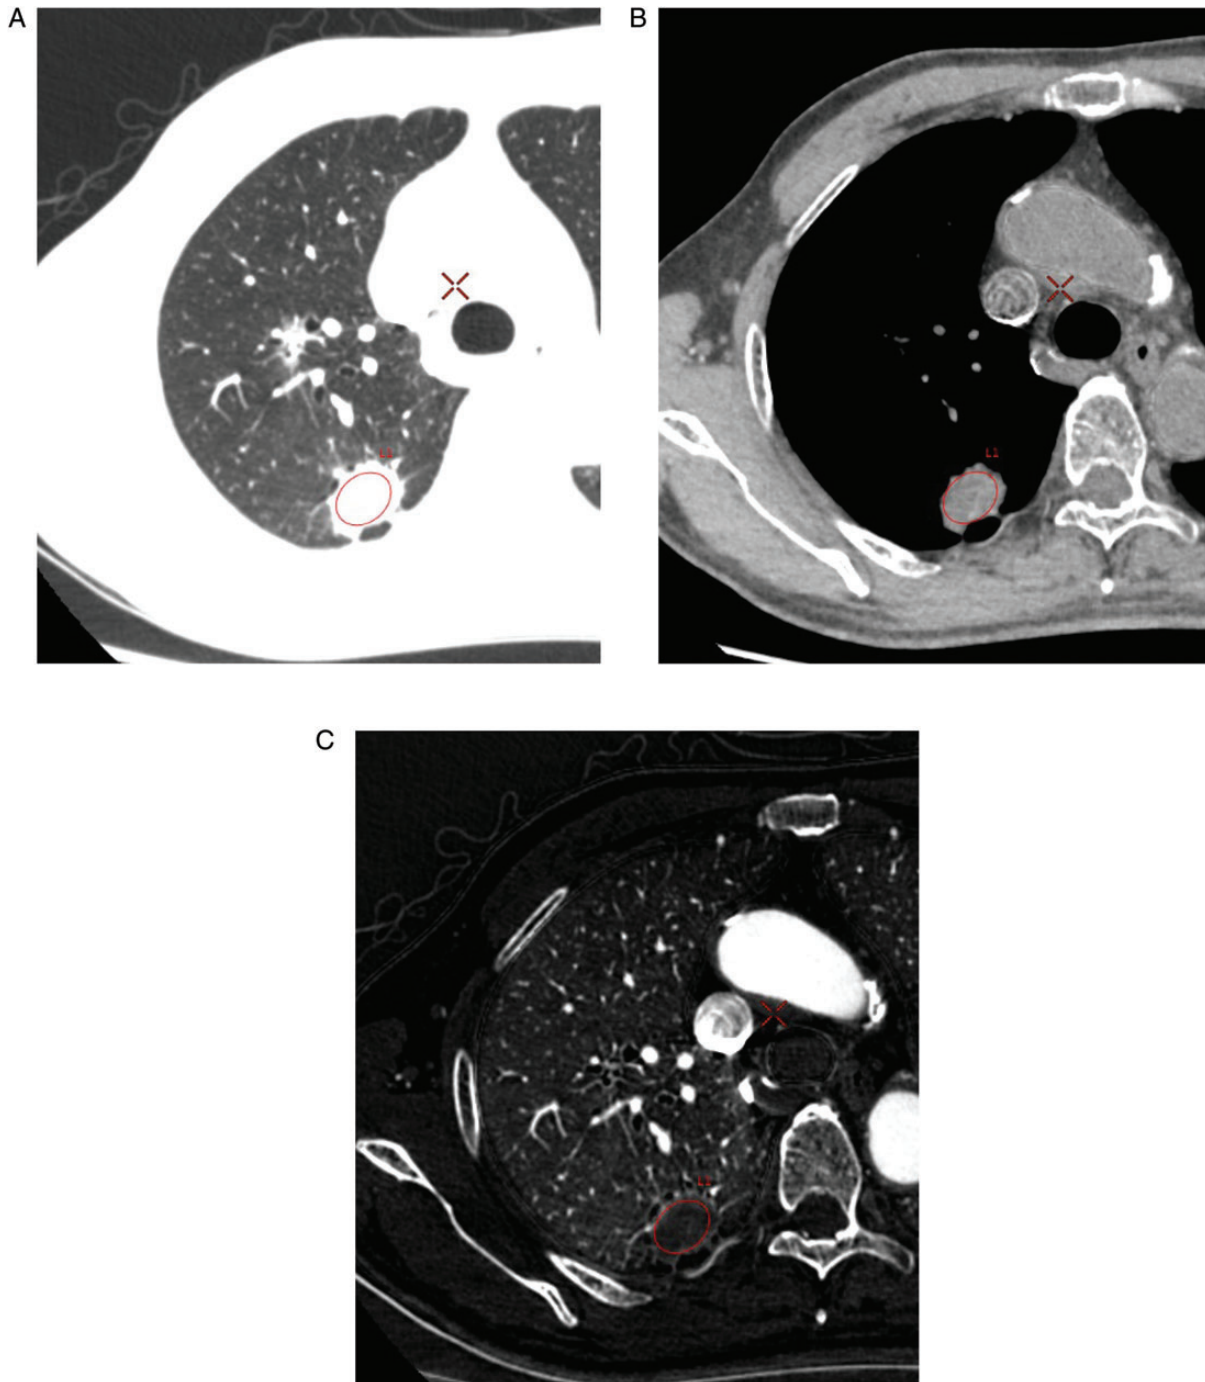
One 74-year-old man with a non-small cell lung cancer. Locations of the ROIs for the lung tumor: CT image of pulmonary window (A); water density image (B); iodine density image (C).
